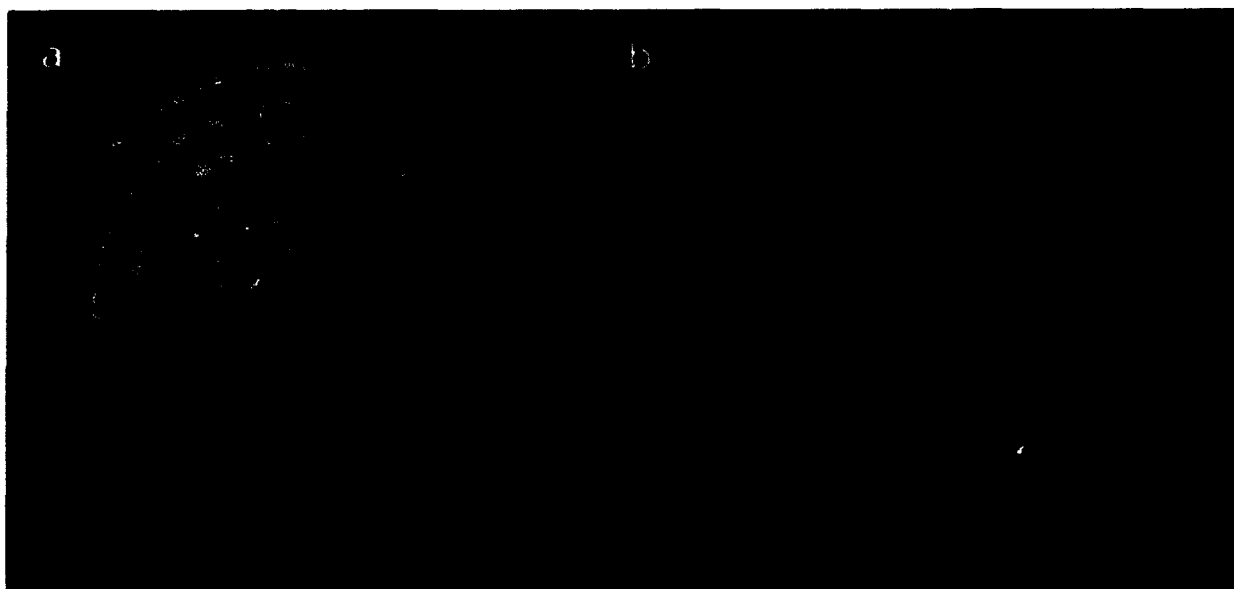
Comparison of (a) measured ⁶⁰Co activity distribution with (b) radiograph of inactive replica filled with approximately 3500 ⁵⁹Co pellets.
